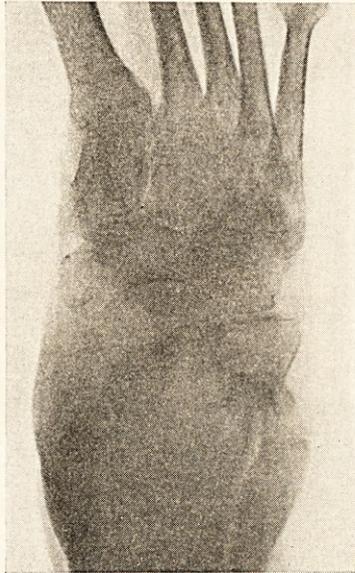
X-ray of tarsus, showing well-marked osteodystrophy at the stage of stippling.
